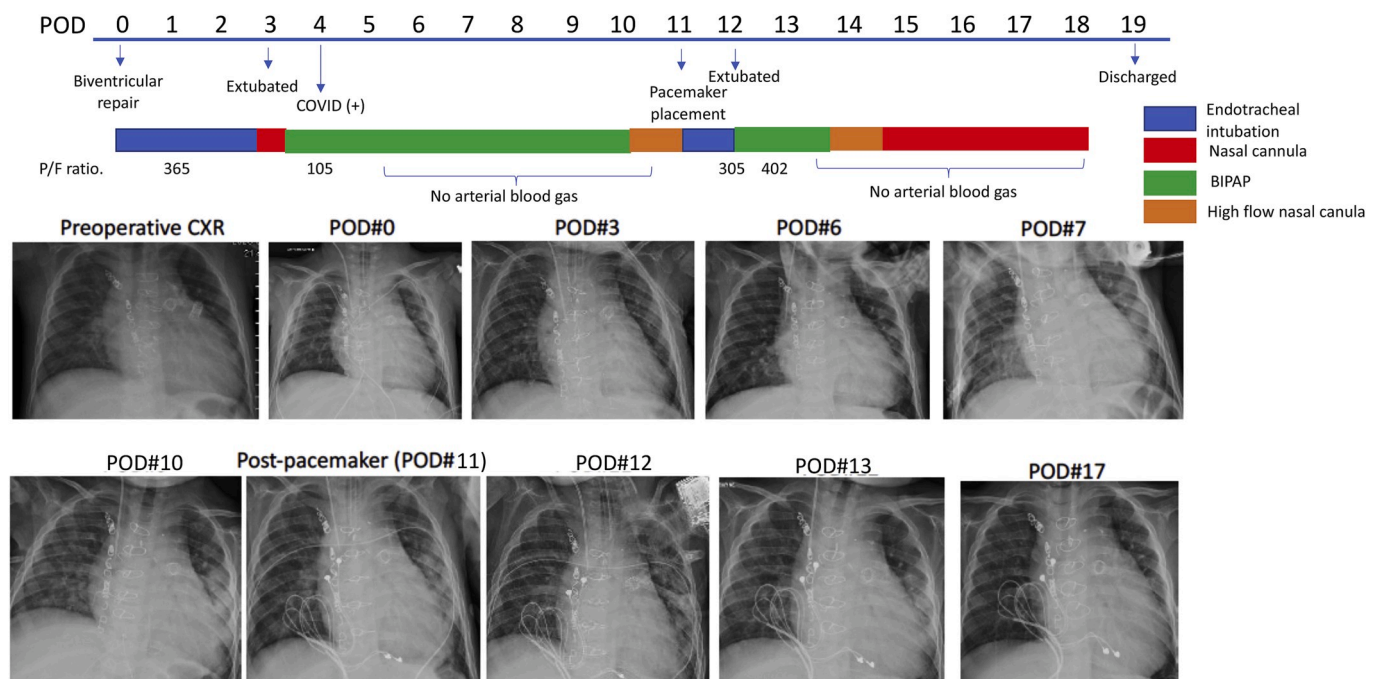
Clinical course of the patient and serial chest X-rays. The clinical course of the patient including respiratory status was shown. POD, postoperative day; P/F ratio, PaO₂/FiO₂ ratio.
